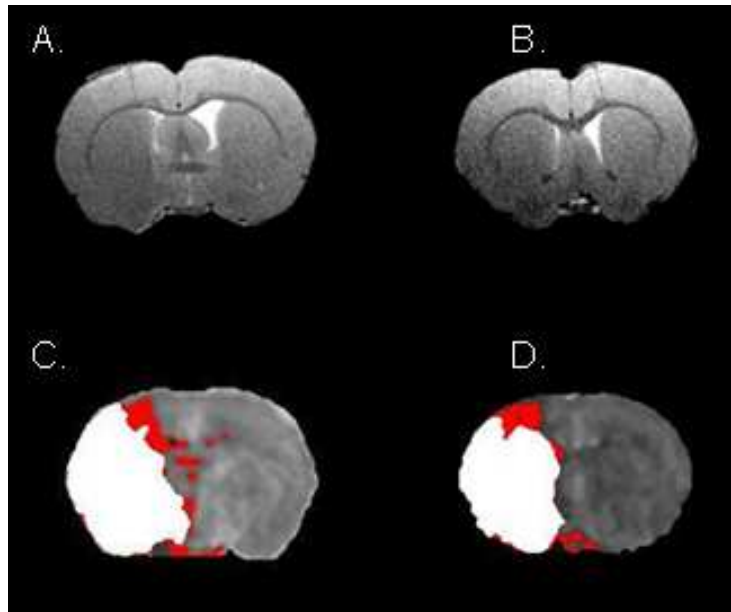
RARE T_2 neuroanatomical templates for caudal (A) and rostral (B) middle cerebral artery territory coronal slices of interest. Corresponding coregistered perfusion-weighted imaging (PWI) and diffusion-weighted imaging (DWI) thresholded images displaying DWI lesion (white) superimposed on perfusion deficit (red), revealing DWI/PWI mismatch areas for caudal (C) and rostral (D) slices. ASL scans were thresholded using a 57% reduction in the mean contralateral values (Meng et al, 2004); whereas the ADC maps were thresholded using a 16.5% reduction in the mean contralateral values (Lo et al, 1997)
